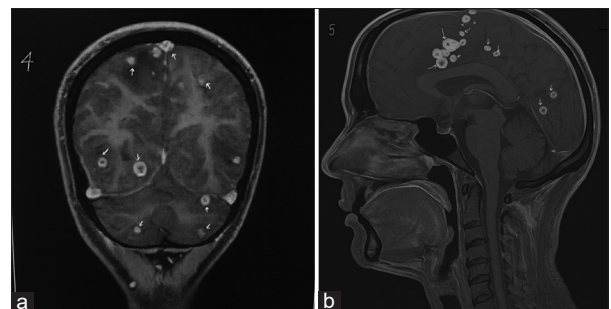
(a) Magnetic resonance imaging (MRI) brain (T1 post-contrast) showing multiple peripherally enhancing tuberculomas; (b) MRI brain showing conglomerated tuberculomas with surrounding edema
